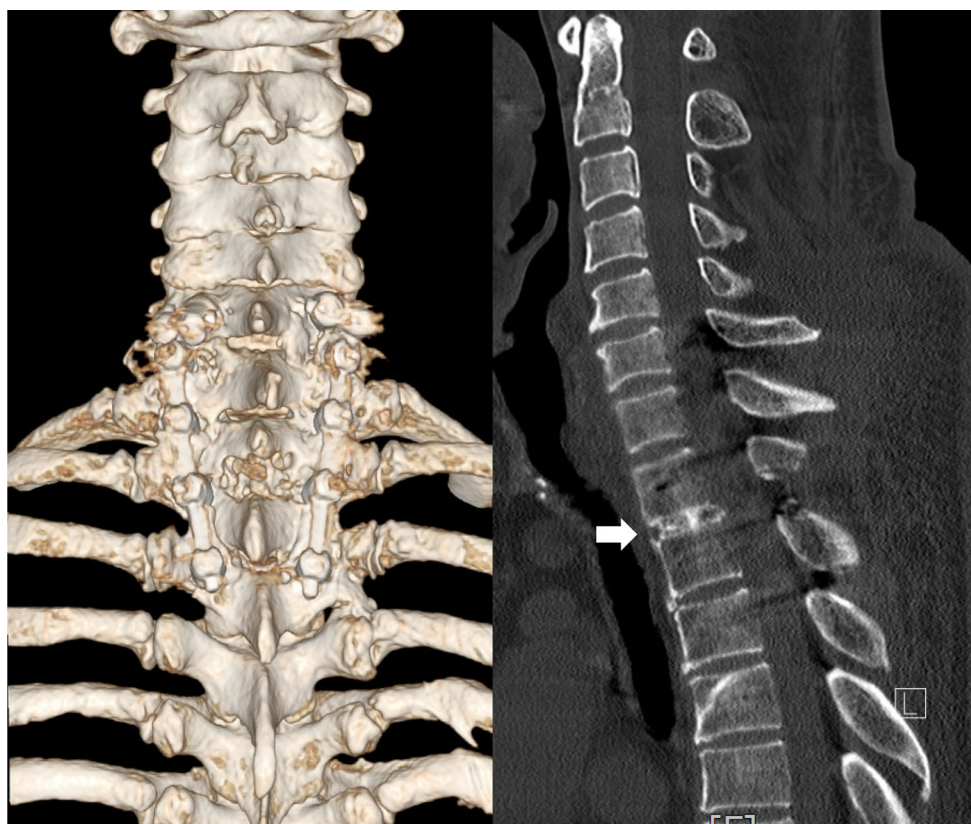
a Three-dimensional CT scan showed solid union was achieved after 6 years post-trauma. b Spontaneous T1–2 interbody fusion was seen on sagittal CT images (arrow)
